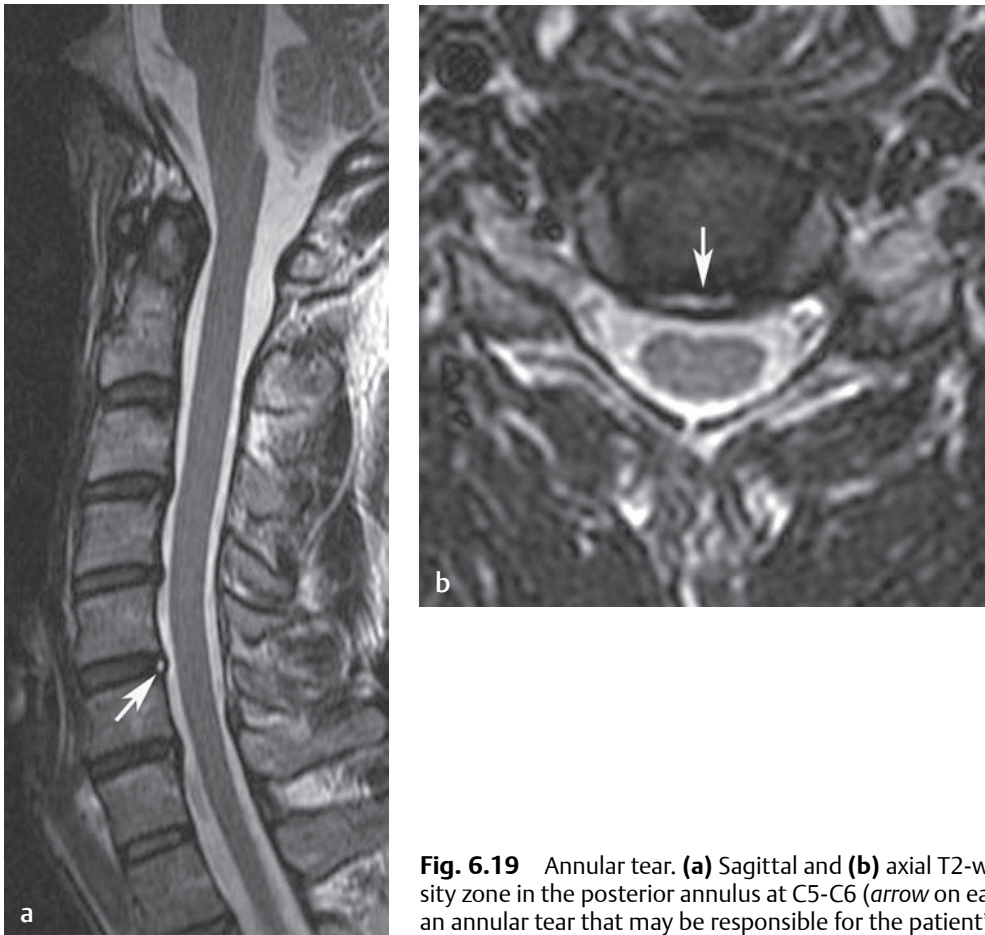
Annular tear. (a) Sagittal and (b) axial T2-weighted images show a high-intensity zone in the posterior annulus at C5-C6 (arrow on each). This finding is compatible with an annular tear that may be responsible for the patient's discogenic neck pain.[†]
